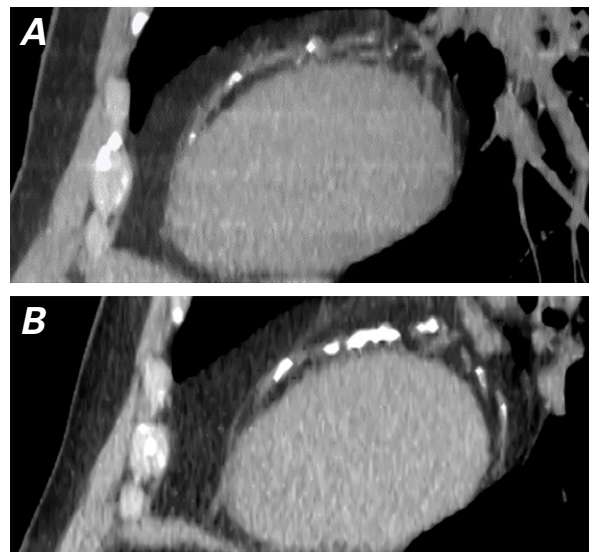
Computed tomographic coronary artery calcium scan (sagittal view) acquired during A) 64-slice scanning shows less coverage and inferior image quality when compared with B) 256-slice scanning.
